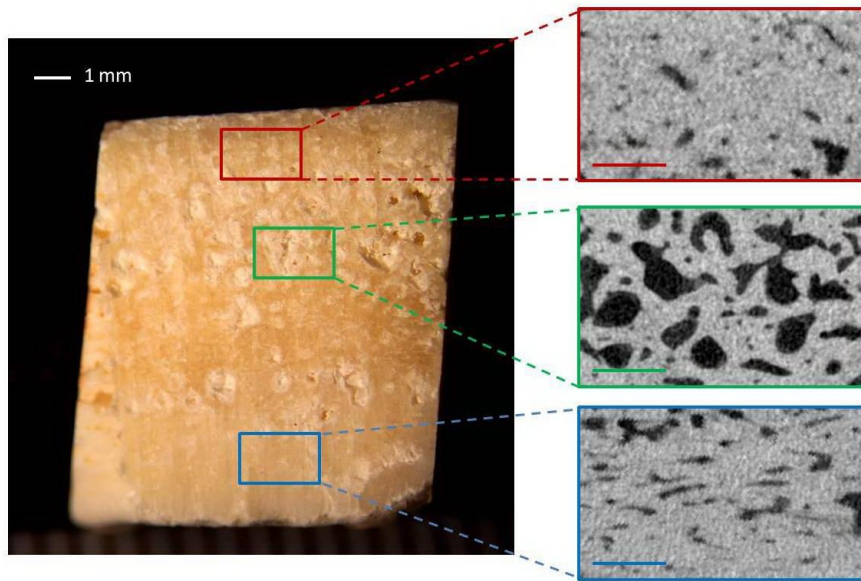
A macroscopic view of the frontal bone sample of woman with HFI (left). Cross-section micro-computed tomography images of the frontal bone outer table (red square), diploic region (green square) and inner table (blue square).
